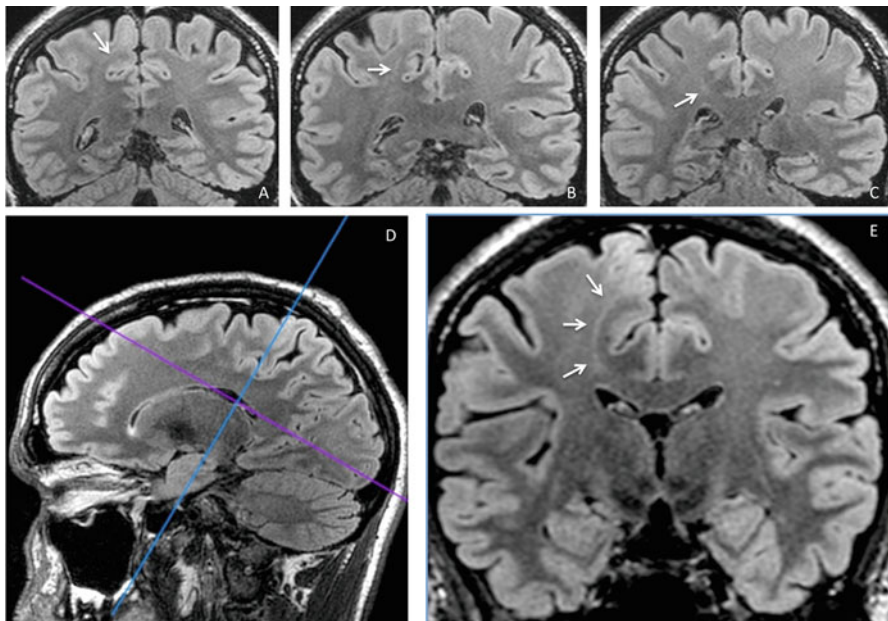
Orthogonal coronal view (a–c) of a 3D FLAIR in a patient with a FCD Type II of the paracentral lobule: the transmantle sign is hardly visible, limited to a thin linear hyper signal. When reformatted in the axis of the dysplastic sulcus (d, e), the transmantle sign is much more obvious, tapering from the cortex to the ventricle wall
